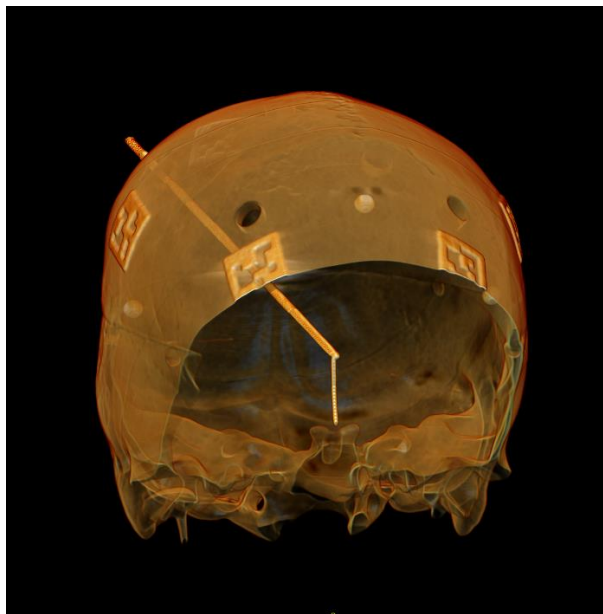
CT scan of post procedure skull and the needle approaches to the targets. Note the AprilTags on the exterior of the skull.
